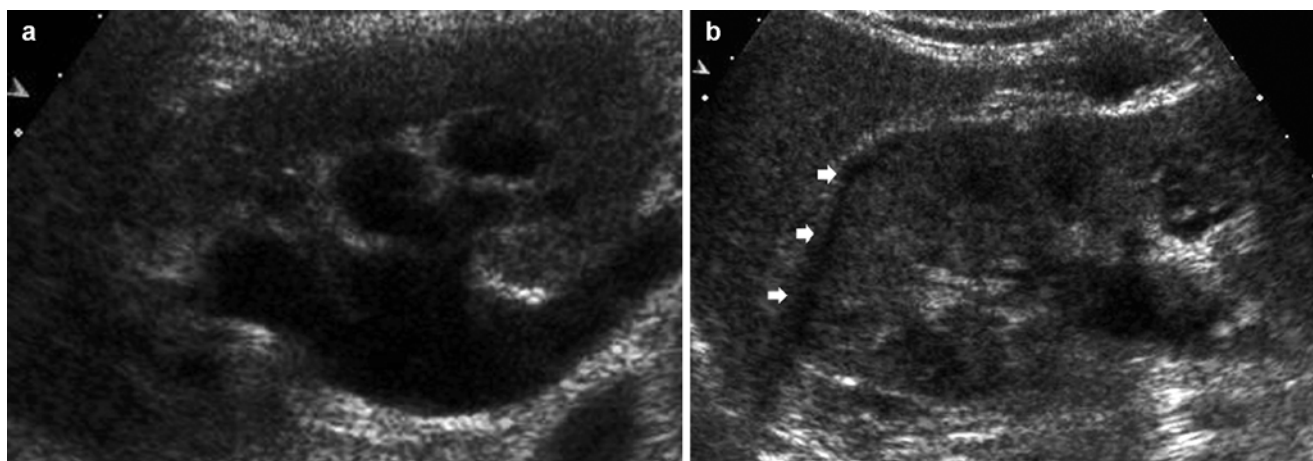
Greyscale ultrasound. Indirect signs of renal colic. (a) Dilatation of the intrarenal urinary tract; (b) subcapsular collections corresponding to urinoma (*arrows*) (Courtesy of Prof. E. Quaia)
